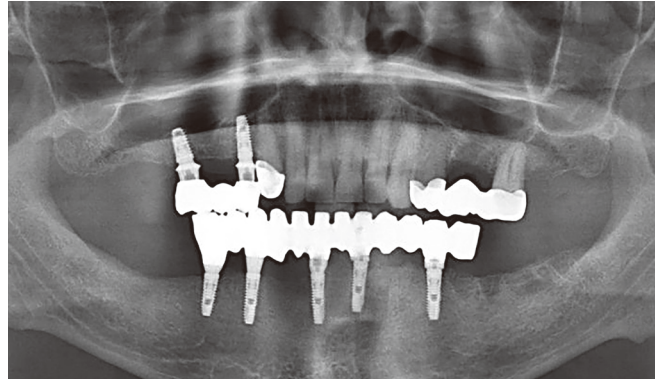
Bite control. An x-ray.
